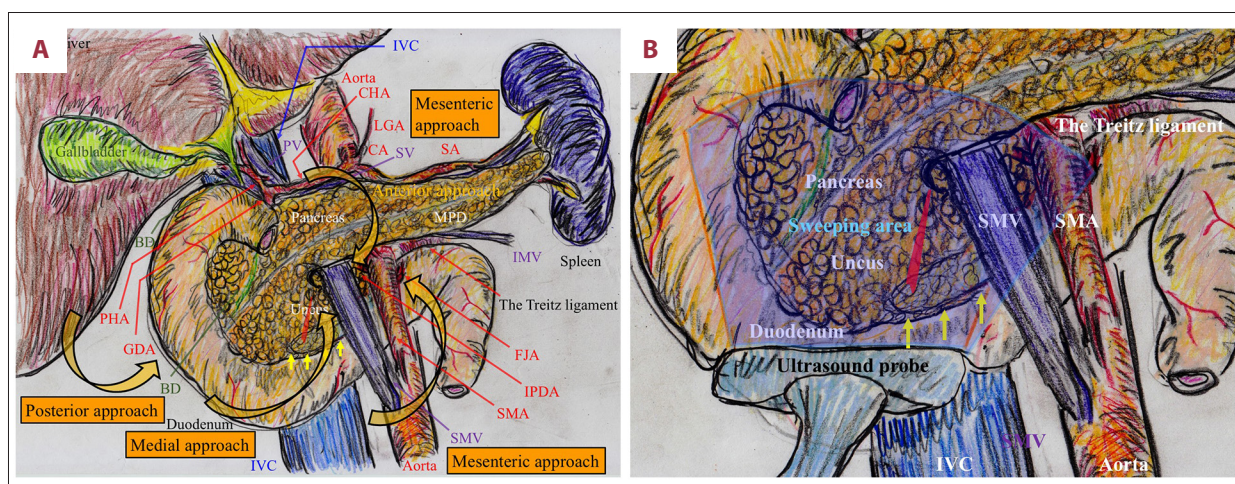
(A, B) Surgical mobilization of the pancreatic head and uncus and the duodenum, and intraoperative ultrasonography. To mobilize the pancreatic head and uncus and the duodenum, a total of 4 surgical approaches were performed. To detect the scad bone, intraoperative ultrasonography with adequate sweeping area was performed. The duodenal diverticulum (yellow arrows) was clearly observed. BD, bile duct; CA, celiac artery; CHA, common hepatic artery; FJA, the first jejunal artery; GDA, gastroduodenal artery; IMV, inferior mesenteric vein; IPDA, inferior pancreaticoduodenal artery; IVC, inferior vena cava; LGA, left gastric artery; MPD, main pancreatic duct; PHA, proper hepatic artery; SA, splenic artery; SMA, superior mesenteric artery; SMV, superior mesenteric vein; SV, splenic vein.
